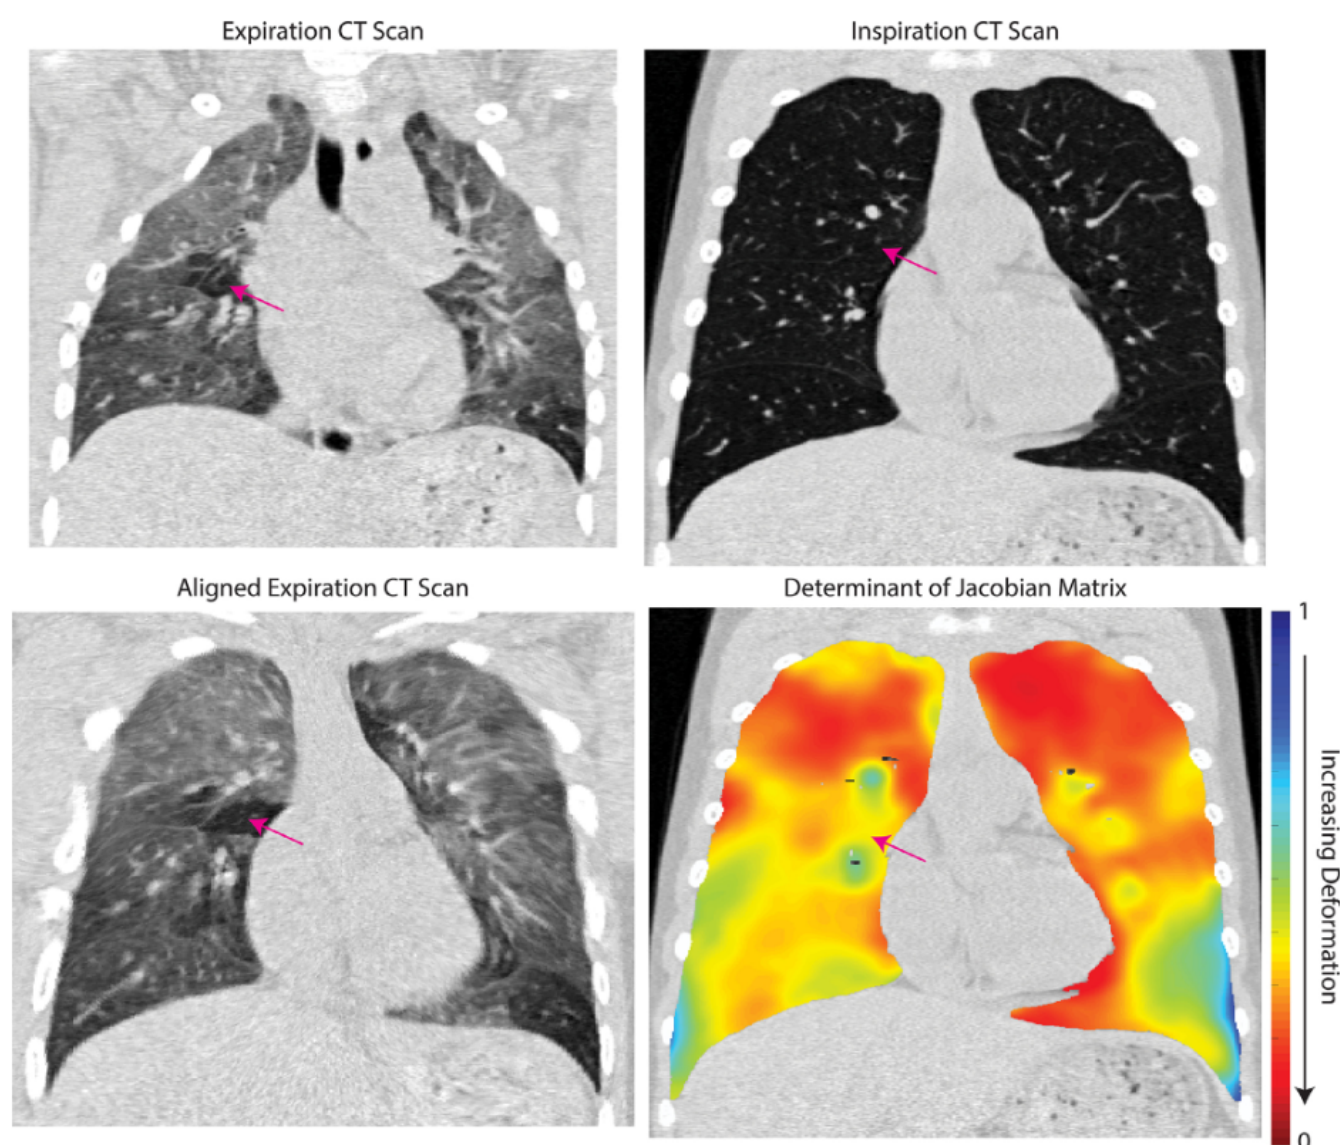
Example of differences in local deformation. Presented are representative coronal slices of the expiration, inspiration, and aligned expiration CT scans with corresponding determinant of the Jacobian matrix map (J) from the same subject as in Figure 3. The magenta arrow indicates the location of regional air trapping on all image slices. Spatial alignment of air-trapped regions requires less deformation than hyper-attenuated parenchyma as indicated by dark red regions on the J map. For reference, $J = 1$ for no deformation, decreasing values ($0 < J < 1$) for expansion and increasing values ($J > 1$) for compression. (Color version of figure is available online.).
